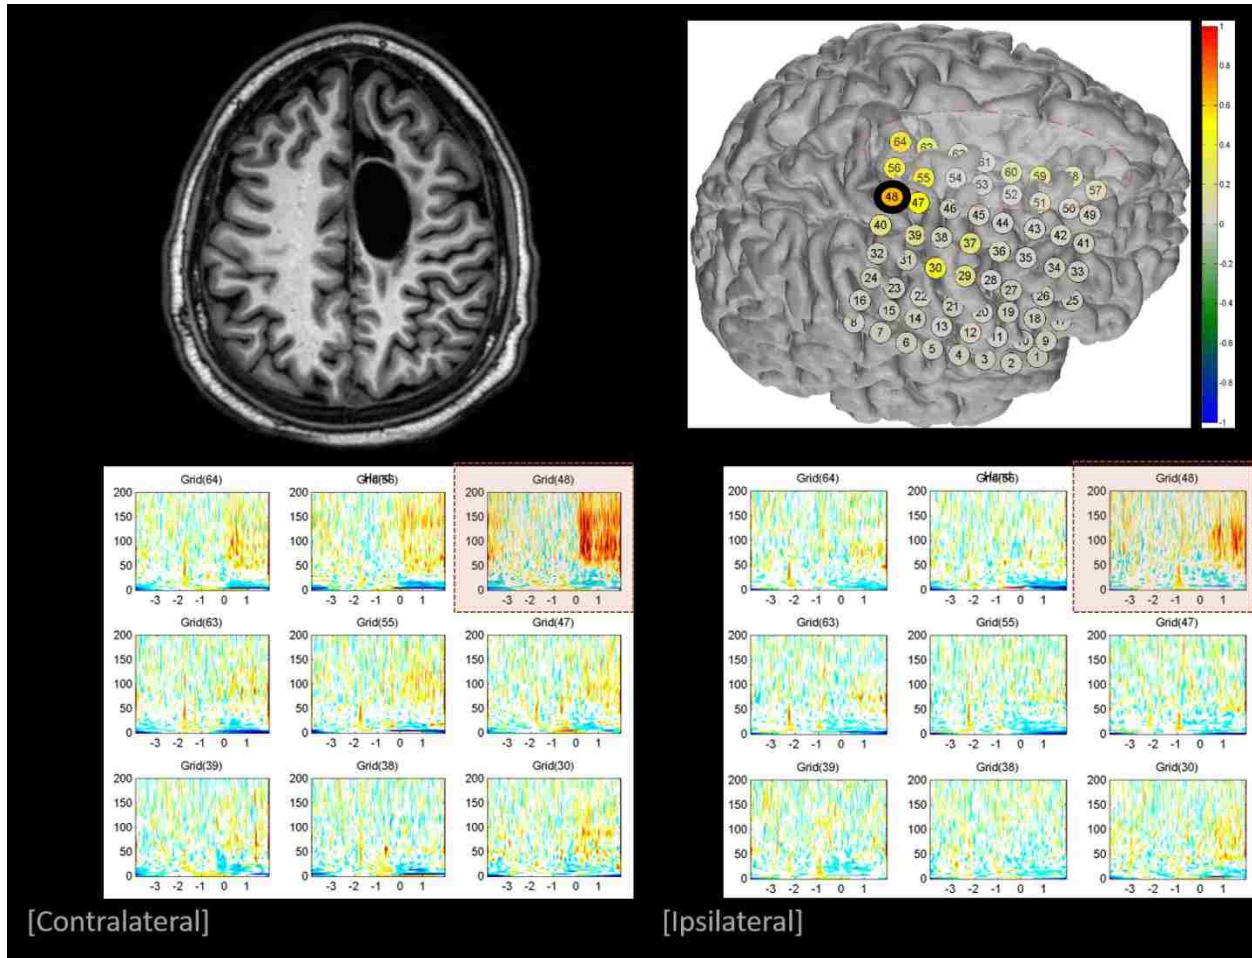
ECoG Implant and Initial Screening. (a) MRI axial slice view (110/187) of the subject's brain, reflected about the y-axis from original clinical view, indicating possible porencephalic cyst corresponding to perinatal infarction of the right MCA. (b) Cortical reconstruction of subject's brain with ECoG implant generated from pre/post-op MRI and CT scans (Wander et al., 2013). The ECoG electrodes consist of 3mm diameter platinum pads spaced at 1cm center-to-center and embedded in silastic (AdTech). Subject was implanted with one 8x8 grid over the central sulcus, one 1x8 strip over the frontal lobe, and one 2x8 strip along the interior. Only the 8x8 grid electrodes were used for experimental purposes. Subject was visually cued to move their left hand, wrist, tongue, and shoulder at 3 second intervals. High Gamma (HG) power (70-100Hz) at each electrode was examined for significant differences between activity and rest conditions. The colored circles show the average responses for left hand movements, which are contralateral to grid. The electrode labeled 48 (in a putative hand motor region) had the highest significance and was chosen for use in BCI control. Similar screening was done with motor imagery as well as with movements ipsilateral to the implanted hemisphere. (c) & (d) Contralateral vs. ipsilateral time-frequency analysis for z-scored HG power responses mapped across a set of grid electrodes. The HG response over time supports initial selection of electrode 48 (highlighted in light red). Most electrodes are quiescent to ipsilateral hand movement. There is activity at electrode 48 for ipsilateral movement but this activity is muted and somewhat delayed compared to the contralateral case.
